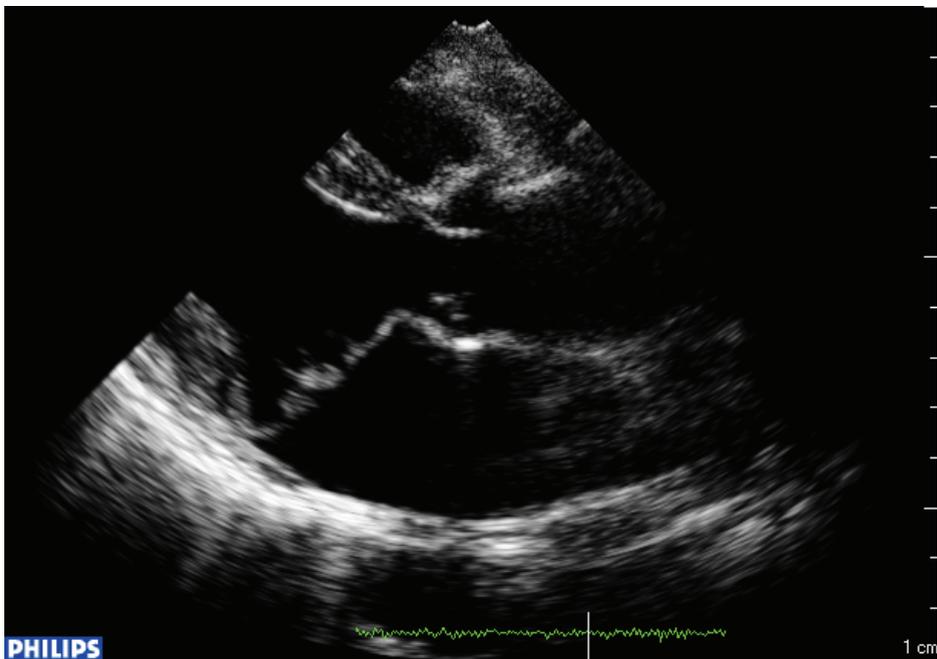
Echocardiogram of RA patient LP female, age 46 - mitral valve prolaps
